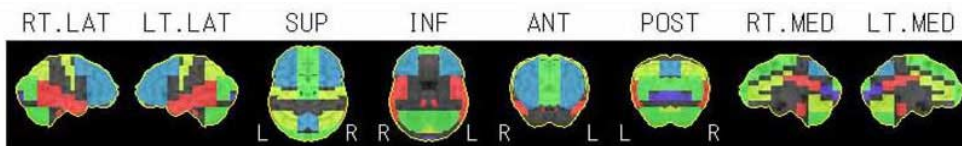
An ET patient: SPECT image. High activity in the basal ganglia is shown.
